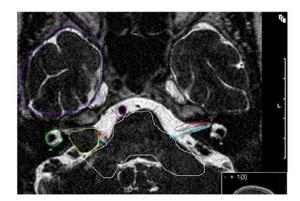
Axial T2 weighted MRI with a still discernible CSF-interface between tumour and brain. The largest diameter of the tumour in the CPA cistem is 14 mm. Yellow: vestibular schwannoma, Green labyrinth, Red: ipsi- and contralateral facial nerve Blue: ipsi- and contralateral vestibulo-cochlear nerve, White: brainstem and cerebellar peduncle Purple: caudal temporal lobe, Pink: basilar artery
